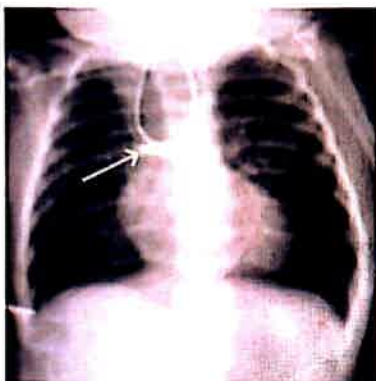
Image showing chest X-ray with the coiled-up feeding tube.
